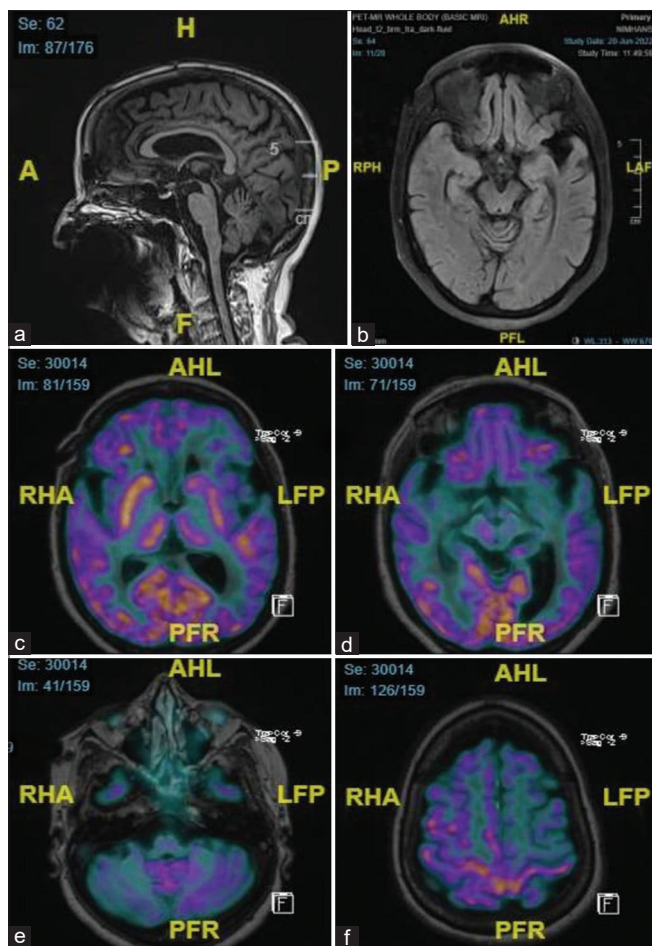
Head T1 MPRAGE sagittal showing the humming bird sign with midbrain atrophy. (b) Head T2 dark fluid transverse showing left side midbrain atrophy. (c) ^{18}F -FDG MR/PET axial fused showing hypometabolism involving the left thalamus, striatum, frontal, and temporal lobes. (d) ^{18}F -FDG MR/PET axial fused showing hypometabolism involving the midbrain left side. (e) ^{18}F -FDG MR/PET axial fused showing hypometabolism involving the right cerebellum. (f) ^{18}F -FDG MR/PET axial fused showing maintained left perirolandic region. ^{18}F -FDG MR/PET: F18-fluorodeoxyglucose magnetic resonance/positron emission tomography
